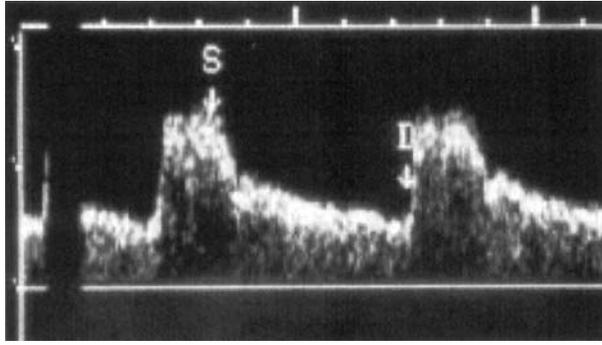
Measurement of RI by duplex Doppler sonography (*S* peak systolic flow velocity, *D* minimum diastolic flow velocity)
